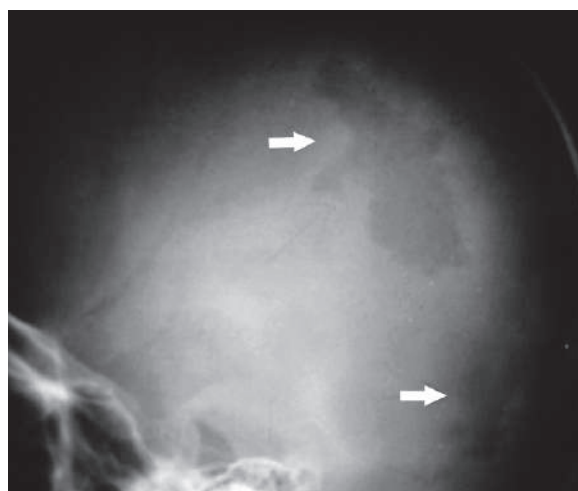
Lateral plain skull radiograph shows two sharply lytic, punched-out lesions with geographic edges (arrows) in a child with eosinophilic granuloma
